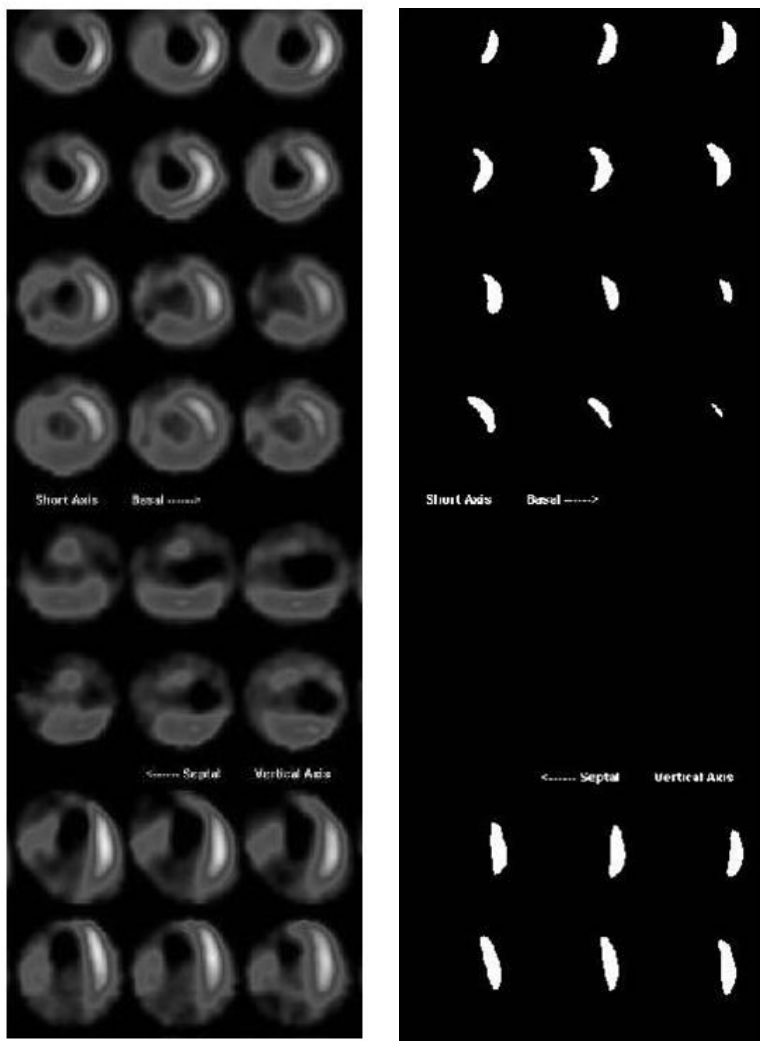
SPECT image slices and binary thresholded image slices
